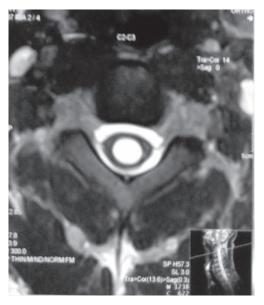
Axial view of MRI T2 weighted image showing hyperintense area inside the spinal cord
